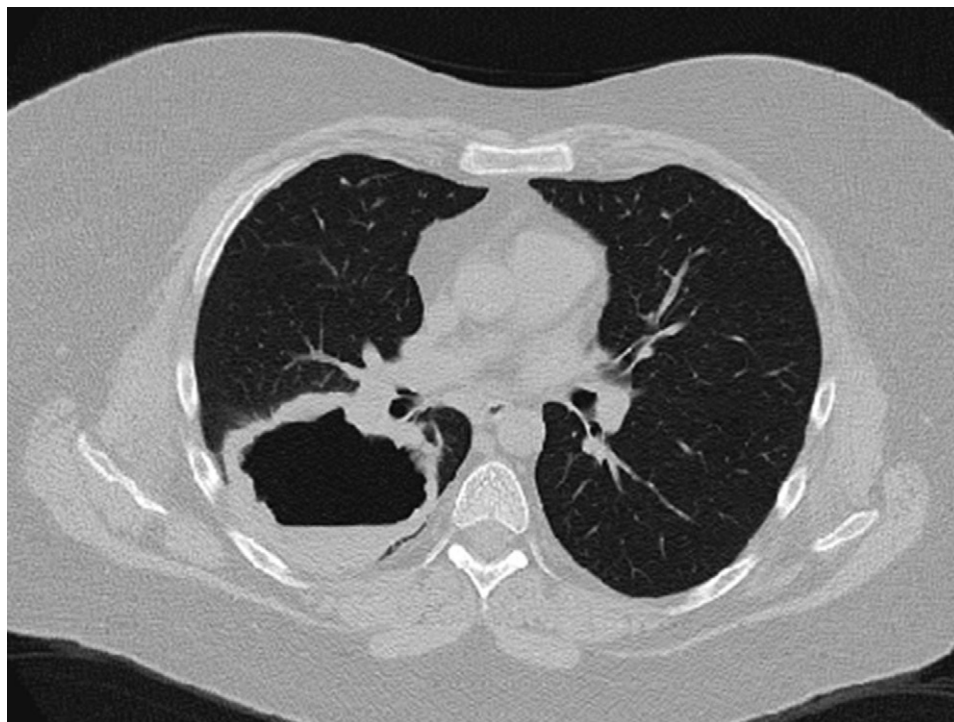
A large cavitary lung nodule seen on a computed tomographic scan in a patient with WG.
